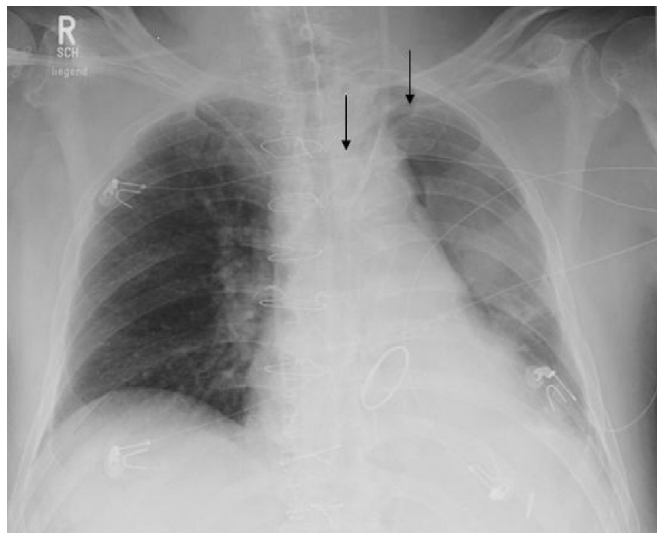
Chest x-ray showing the position of the left subclavian central line (arrow).
